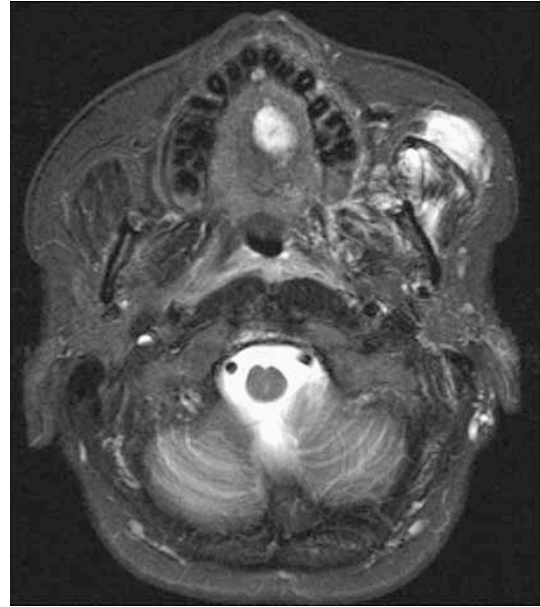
Axial STIR MRI sequence taken at the level of the maxilla. Abnormal high signal representing the lymphatic-venous malformation is present within the left maxilla, pterygoid, masseter, and tongue muscles.
